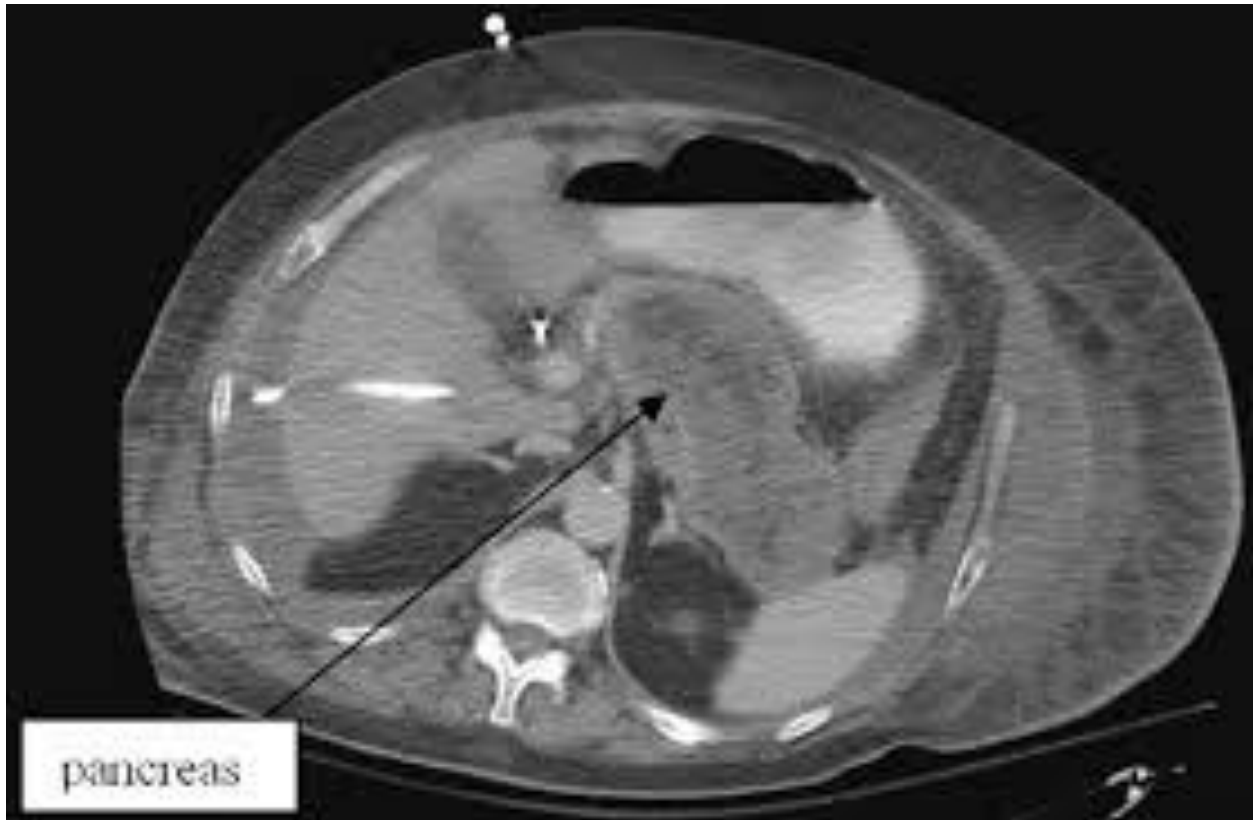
CT ABDOMEN IMAGE SHOWING INFLAMMED PANCREAS WITH PERIPANCREATIC FAT STRANDING
